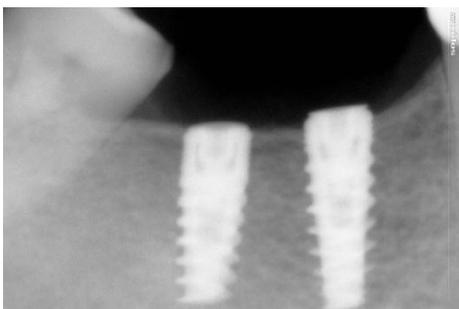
D :Radiograph after implant placement
